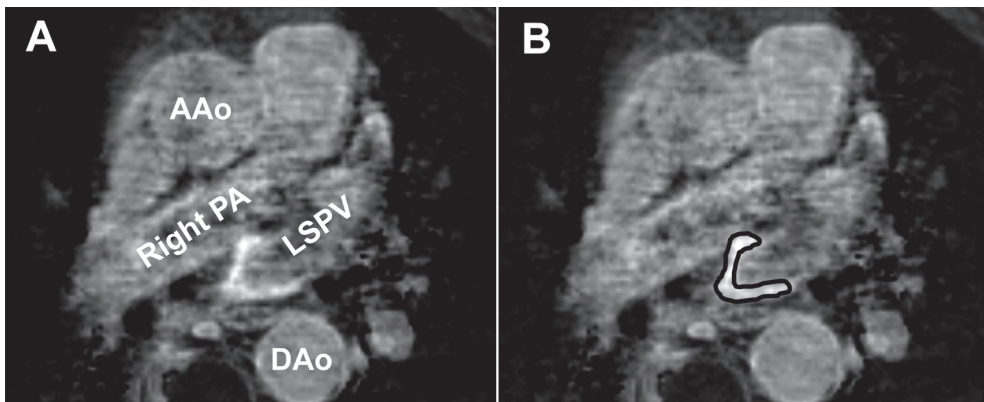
Delayed enhancement magnetic resonance imaging of the left atrium, in axial view, in a patient after pulmonary vein antrum isolation. A: an area of hyperenhancement is seen around the ostium of the left superior pulmonary vein. B: the area of hyperenhancement is manually encircled in order to calculate the amount of left atrial fibrosis. AAO= ascending aorta, DAo = descending aorta, LSPV = left superior pulmonary vein, Right PA = right pulmonary artery.
